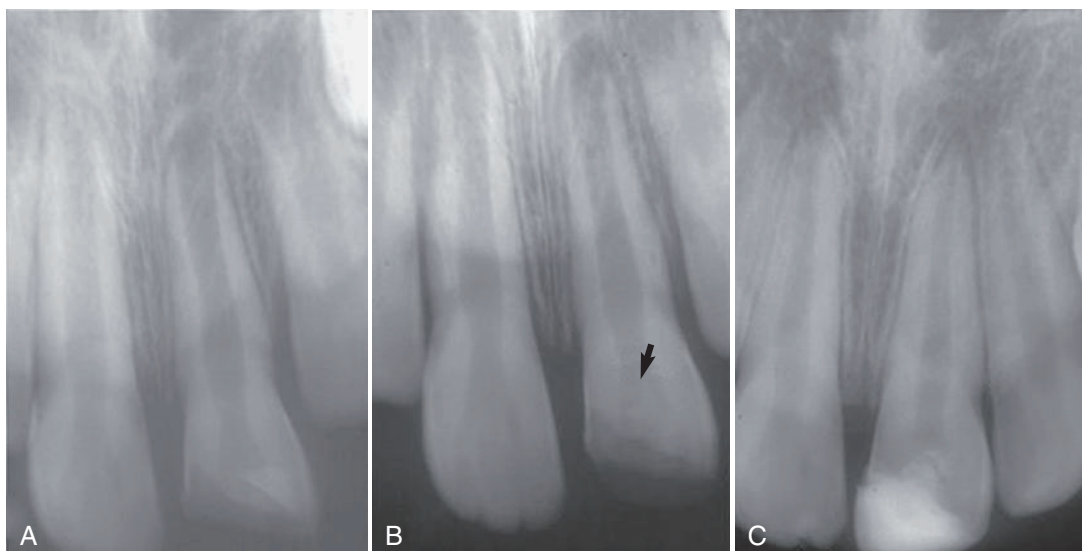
Continued root development after partial pulpotomy. A, Radiograph of immature tooth with a complicated crown fracture. B, At the time of placement of calcium hydroxide after partial pulpotomy. C, Follow-up radiograph confirming that the pulp maintained vitality and the root continued to develop.
